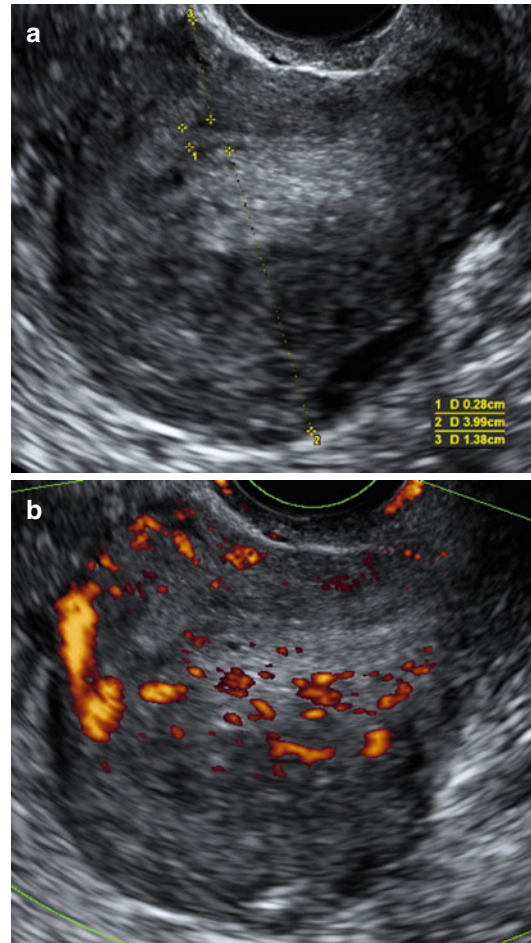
Ultrasound images of a uterus with adenomyosis. (a) Gray scale image showing asymmetrically thickened, posterior wall (2) is thicker than anterior wall posterior uterine wall 3, with inhomogeneous, irregular myometrial echotexture due to hyperechoic and small cystic anechoic areas. Endometrial thickness (J). (b) Power Doppler image showing diffusely spread small vessels
